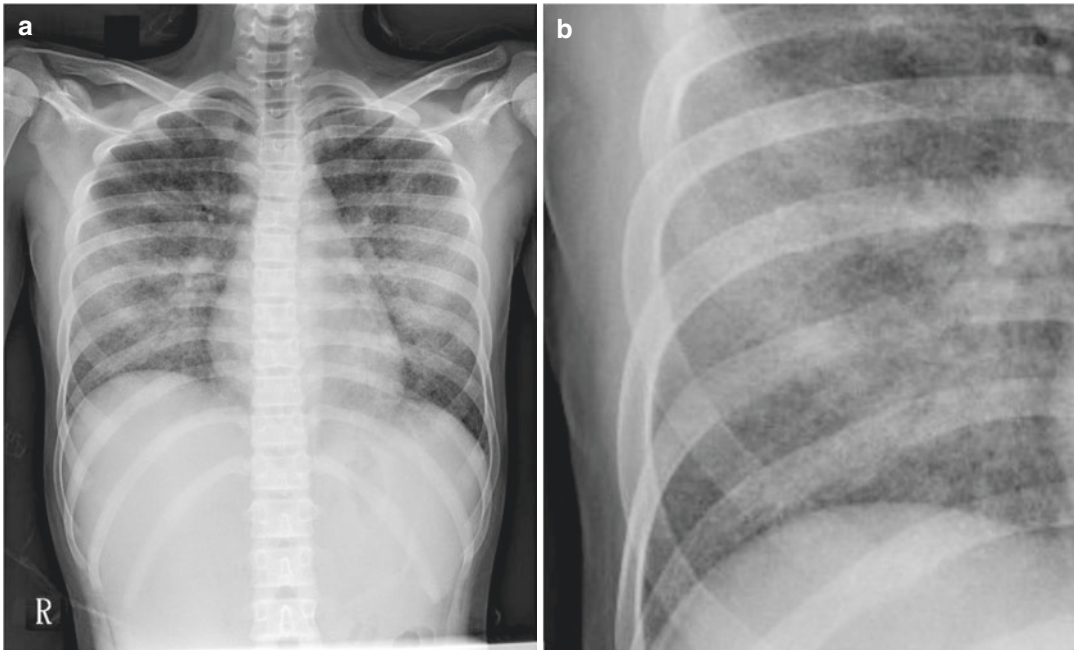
Chest X-ray taken at admission. (a) The chest film shows bilateral interstitial infiltration; (b) Magnified image of right lower lung field of the same chest film shows “military” lesions
